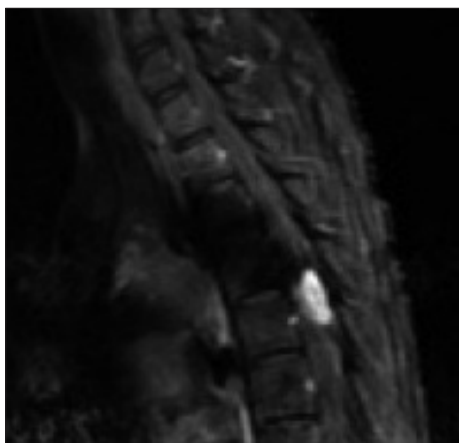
Contrasted T1-weighted magnetic resonance study shows the spinal metastasis.
